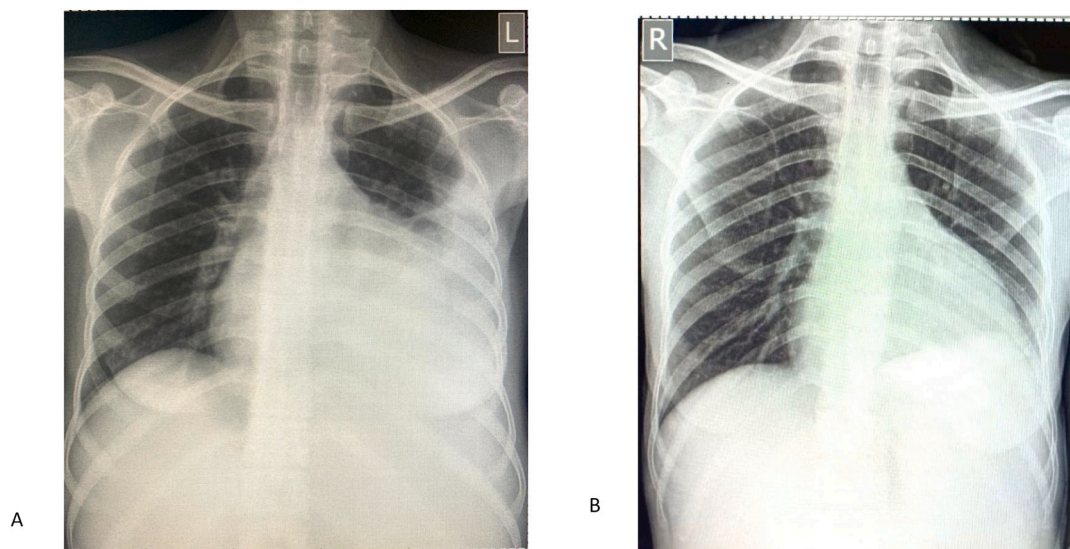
A) Chest X-ray showing right perihilar and paracardial infiltrates, fibrosis, and cavity on left perihilar suggestive of pulmonary TB. The whiteout left lung field revealed pleural effusion B) Chest X-ray post-operatively revealed resolution of the left pleural effusion.
